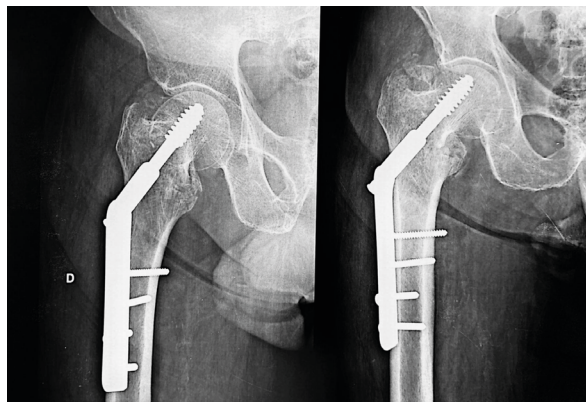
Lateral and AP radiographs of the right hip 45 days after surgery, showing maintenance of the fracture reduction and implant without fatigue or migration.
